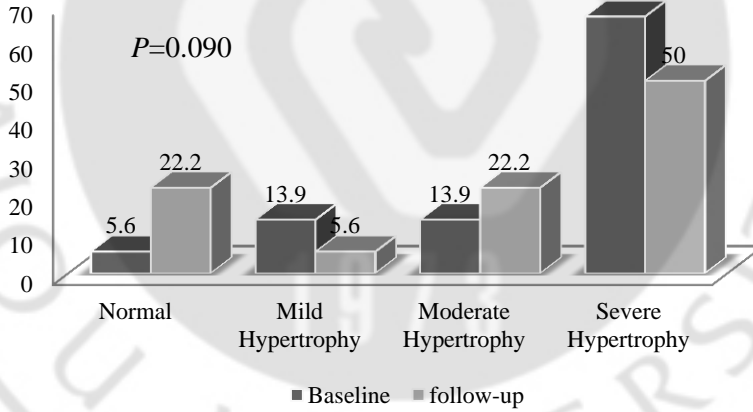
Comparison of severity of LVH at baseline and follow-up echocardiography
